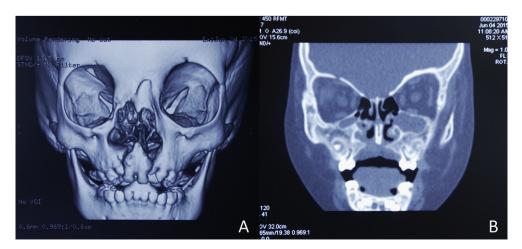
3D CT scan of the skull of Case 1 patient at 2 years 11 months of age. (A) 3D view shows nasal bone and maxillary bone deformities (especially on the right side). (B) 2D view shows marked reduction in right maxillary sinus pneumatization.
